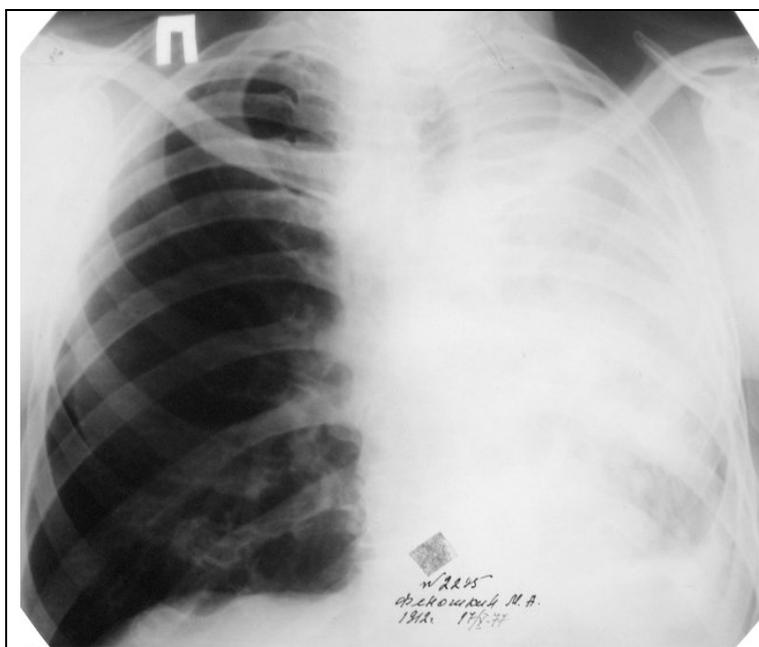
Total shadow in the left pulmonary field. Post-anterior chest radiograph of a patient with obstructive atelectasis of the left lung due to central bronchogenic carcinoma.
